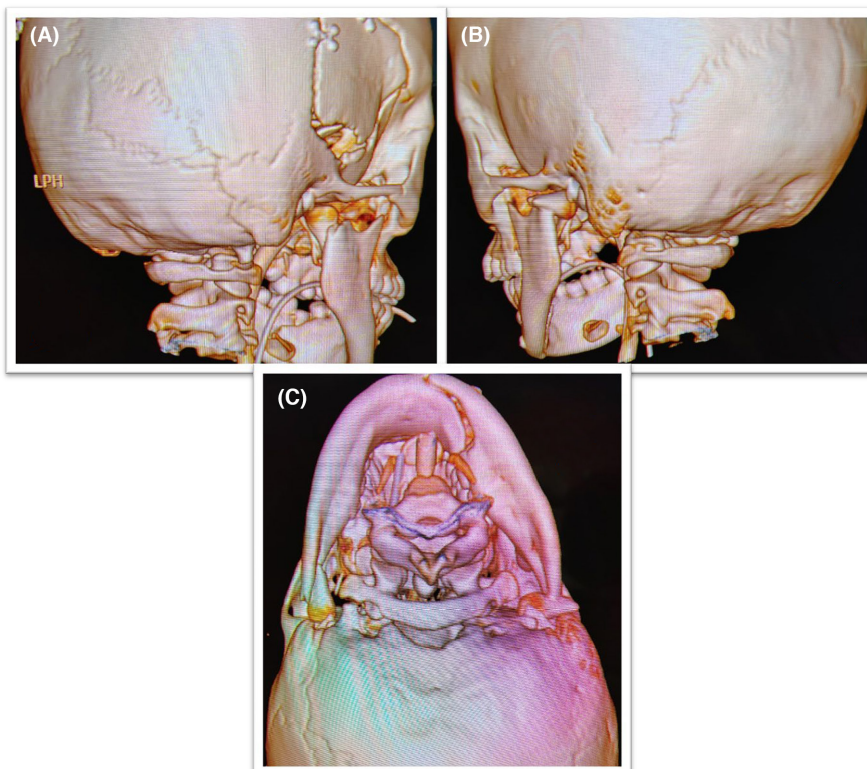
CBCT with 3D-imaging shows preoperative of (A) the right condylar fracture where the condyle was totally displaced, (B) the left condyle was displaced by a 90-degree angle, and (C) the left mandibular body was fractured.
